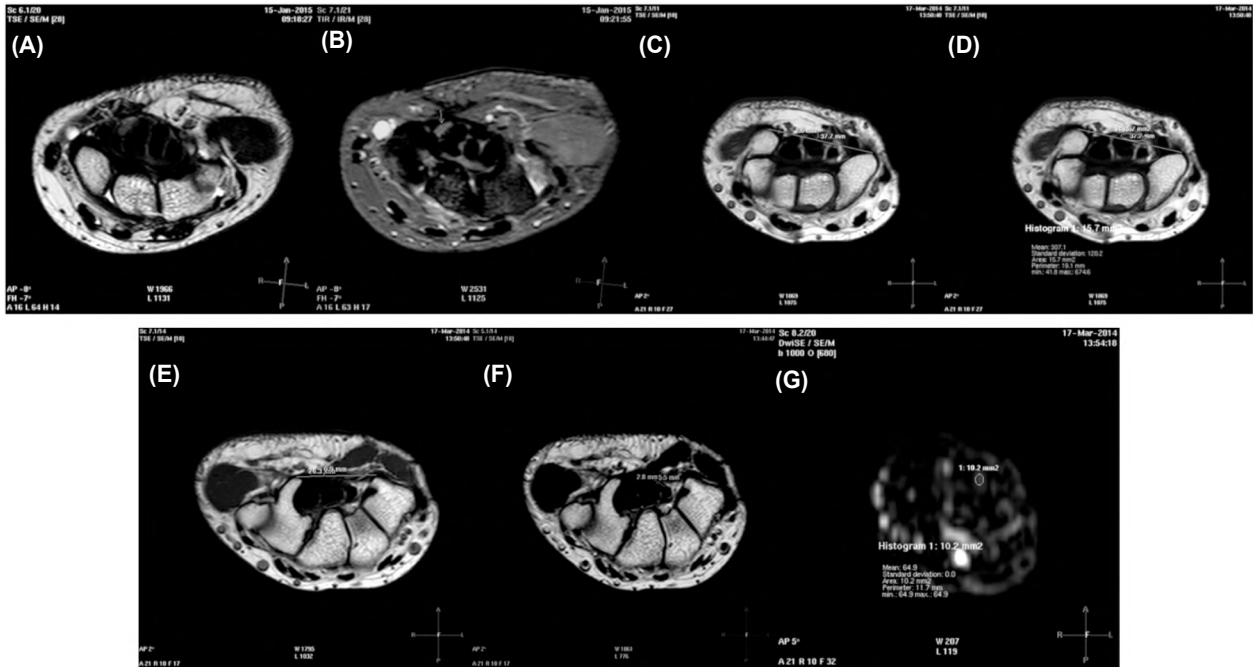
A 34-year-old male subject with no history of hand parasthesia or pain. He had negative Phalen, Tinel and Durkan's tests as well as negative EPS results. (A,B) Axial T2 and PD with fat suppression WIs show MN signal intensity was similar to the thenar muscles (C,D) Axial T 1 WIs at the level of CT inlet shows FR bowing height was 2mm and bowing area of 15.7mm<sup>2</sup> (E) Axial T 1 WIs at the level of CT outlet shows FR bowing height was 0.9mm (F) Axial T 1 WI shows MN flattening ratio at the level of hook of hamate was 1.96 (G) Axial DWI shows CSA of the MN at the level of pisiform bone was 10.2mm<sup>2</sup>.
